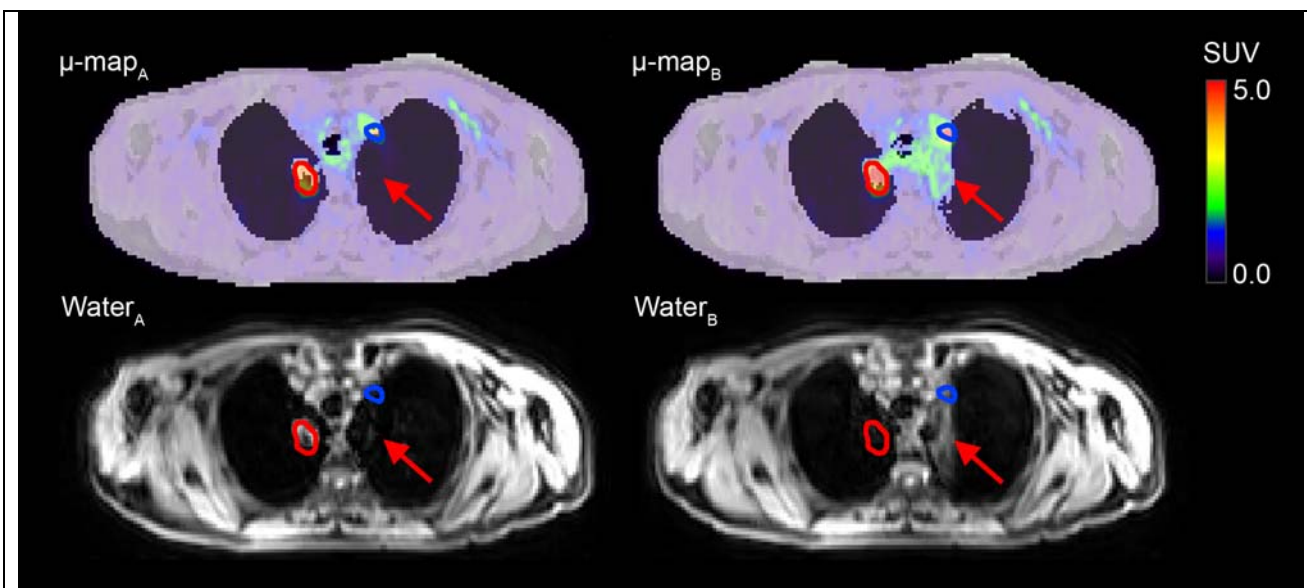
Patient 9, examination 1. Intra-subject repeated MR-AC maps ( $\mu\text{-map}_A$  and  $\mu\text{-map}_B$ ) fused with  $\text{PET}_A$  and  $\text{PET}_B$ , along with their respective Dixon water images.  $\Delta\%SUV_{\max}$  of 12% (tumor delineated in red), 36% (tumor delineated in blue). Red arrows indicate noteworthy differences in the paired MR-AC maps and the Dixon water images.
